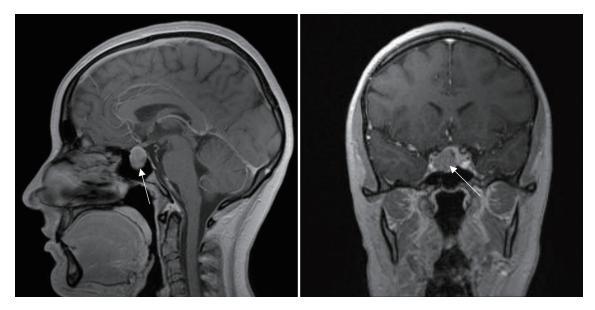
Magnetic resonance imaging examination showing hypophysial prolactinoma, suprasellar formation till optic chiasma (arrow).
